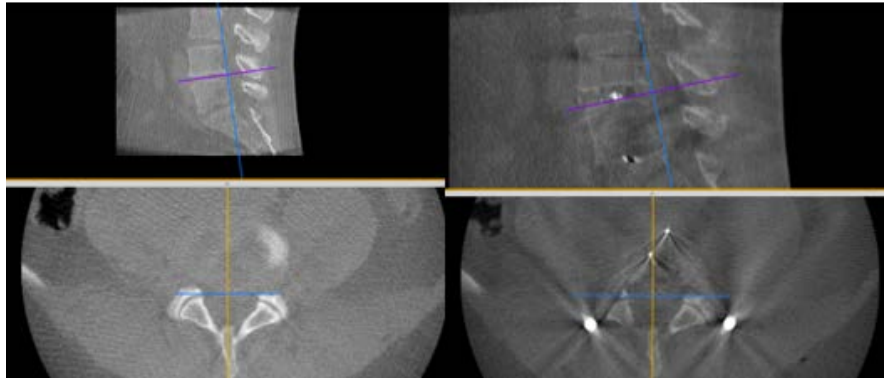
Pre and postoperative CT scan study demonstrating the changes after the placement of the interbody cage and the resection of the articular processes respecting the lamina ipsilateral to the approach.
